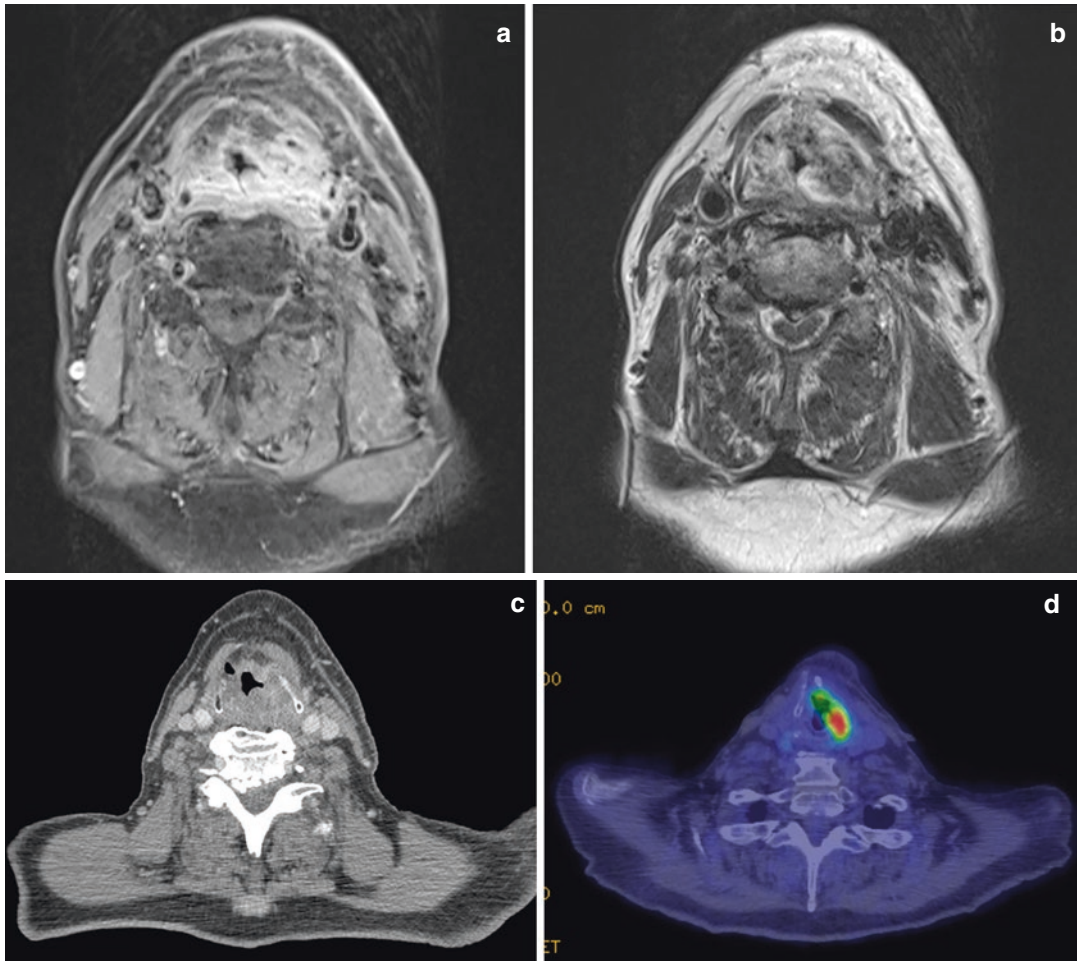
MRI, CT, and PET-CT of a patient with a left transglottic tumor recurrence. (a) T2 MRI. (b) T1 post-contrast MRI. (c) CT with contrast. (d) PET-CT
